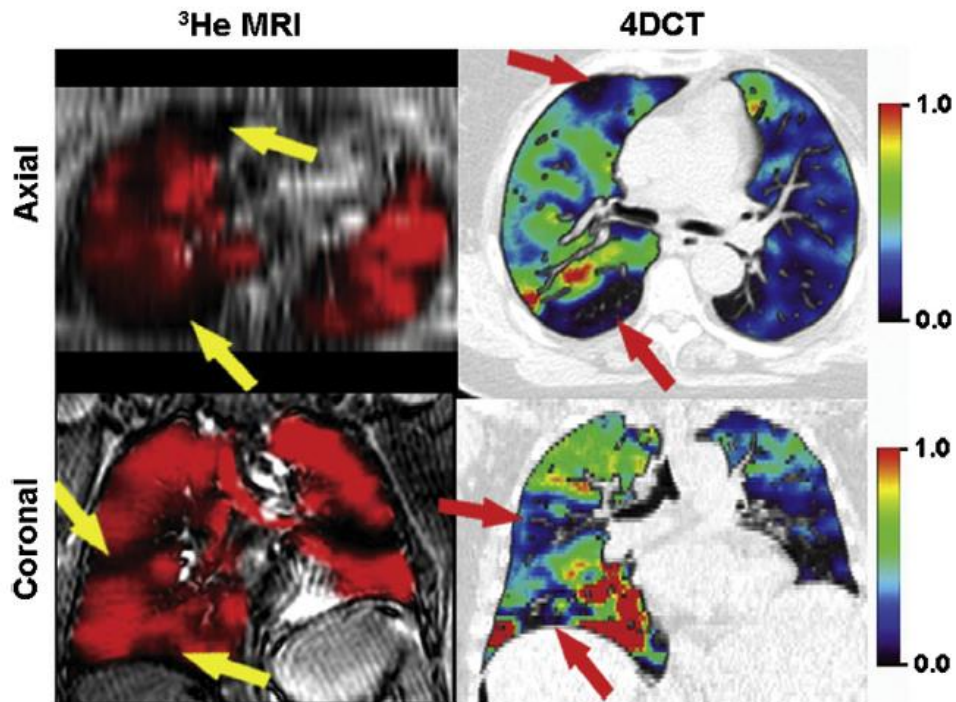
Comparison of 4D-CT ventilation with ^3He MRI ventilation. Arrows indicate matching ventilation defects. Reproduced with permission from Mathew *et al.* (2012).
